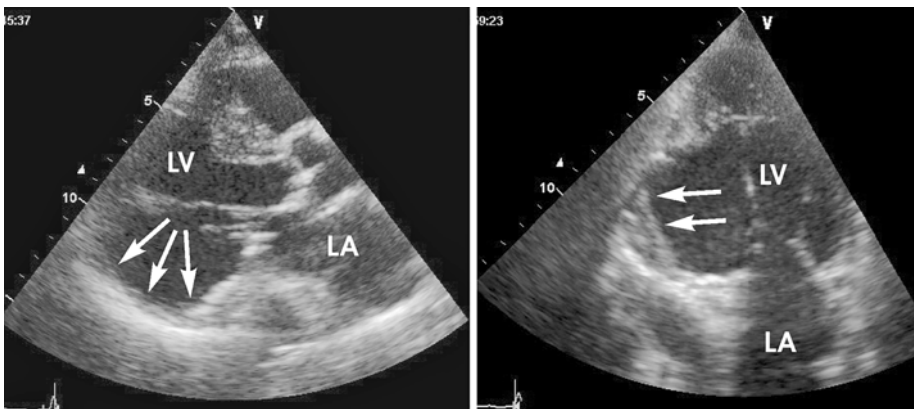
Left ventricular inferior wall aneurysm in a patient with cardiogenic shock. Left: long axis view; right: apical 2 chamber view. Note the large aneurysm at the basal inferior wall (arrows). LA, left atrium, LV, left ventricle
